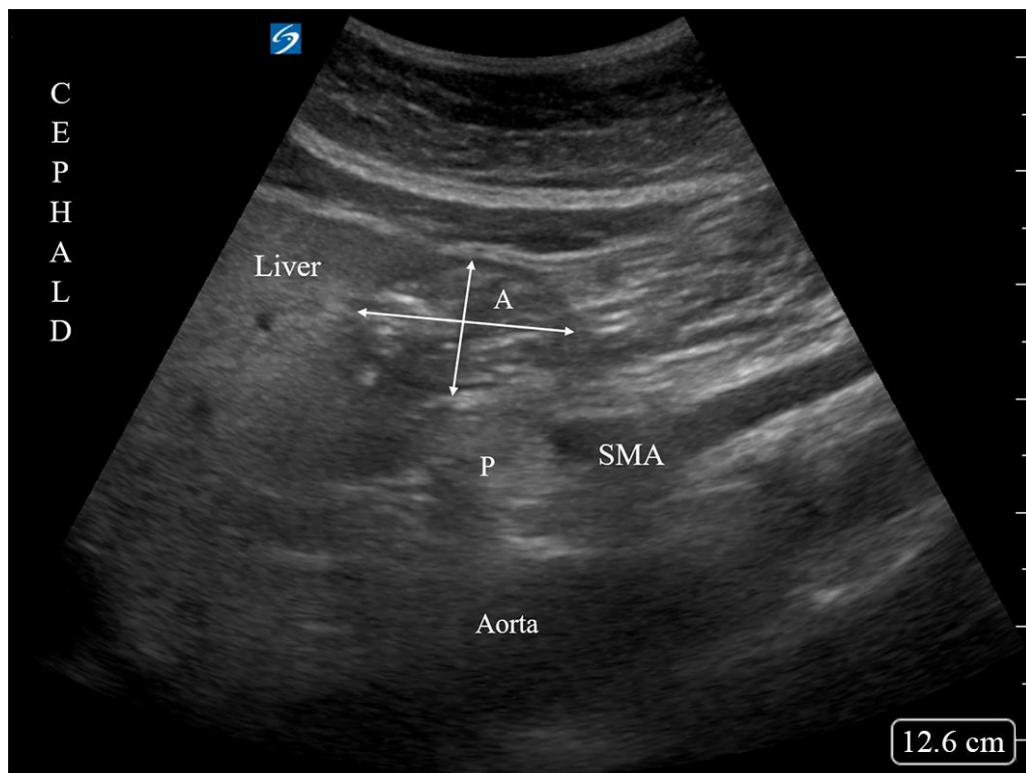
Ultrasonographic measurement of the gastric antrum (A, antrum; P, pancreas, SMA, superior mesenteric artery)
